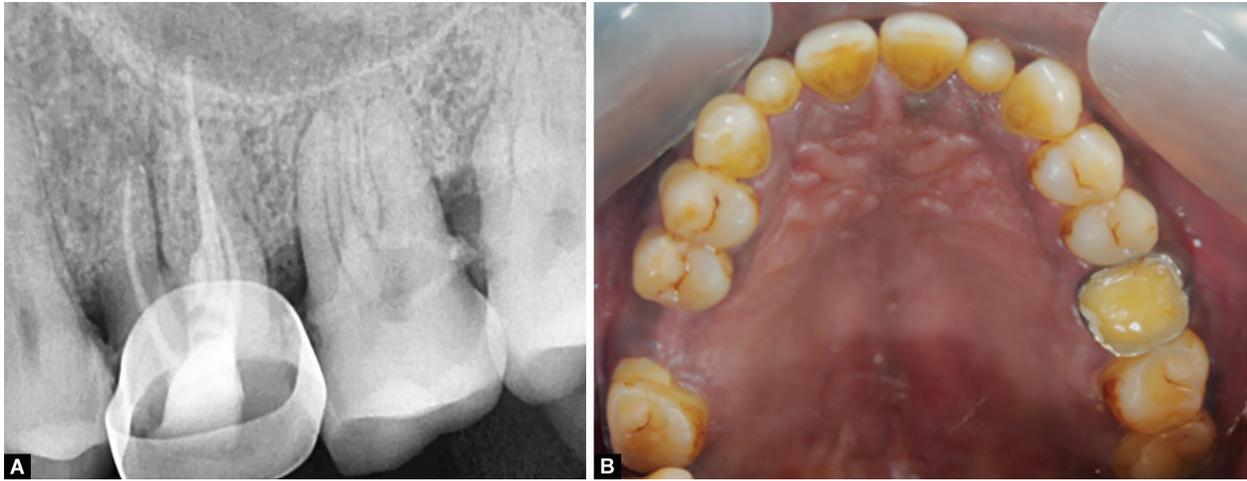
Preoperative radiograph showing extension of the crack line
